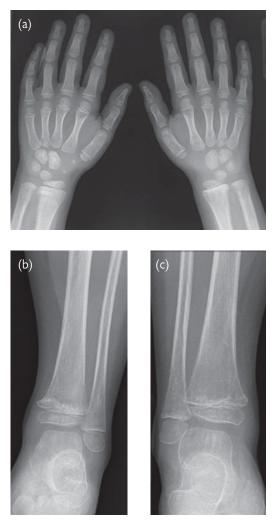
X-ray images of ALL. The bones are osteopenic. There is periosteal reaction along both distal radius and ulna (a). There is patchy metaphyseal sclerosis and lucency of both wrists (a), also at both ankle joints (b, c). Faint periosteal reaction is visible along the lateral distal tibia (c).
